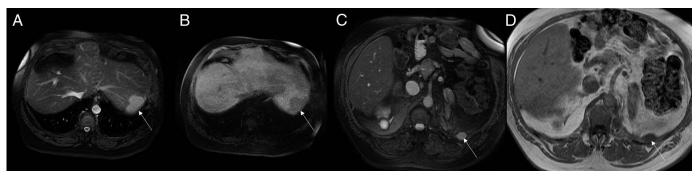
Axial (A) T2-weighted fat-suppressed and (B) T1 fat-suppressed magnetic resonance imaging revealed a lesion (arrow) in the left lobe of the liver. Axial (C) T2-weighted fat-suppressed and (D) T1 weighted magnetic resonance imaging revealed similar lesions (arrow) in the posterior abdominal wall (only 1 lesion measuring 1.5 cm shown).
